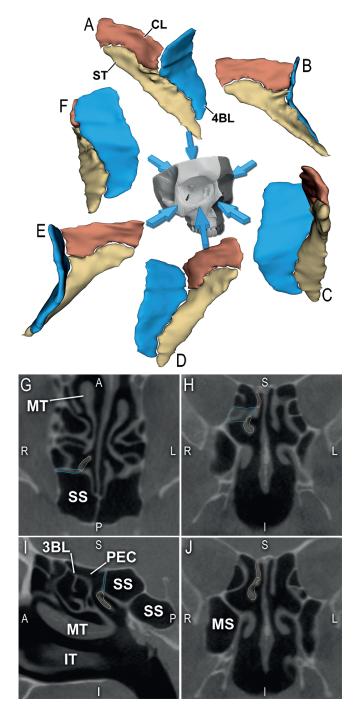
The basal lamella of the superior turbinate, right side. View from superior-posterior-medial (A), medial (B), anterior (C), inferior-anterior-lateral (D), lateral (E), posterior (F). (G) axial CT image of the same individual with frontal (H, J) and sagittal (I) reconstructions. Yellow: superior turbinate, brown: conchal lamina (depicted only in the neighboring area), blue: basal lamella of the superior turbinate (4BL). In most cases the frontal component of the 4BL was pentangular (C, I). 3BL: basal lamella of the middle turbinate (MT), IT: inferior turbinate, MS: maxillary sinus, PEC: posterior ethmoidal cell, SS: sphenoid sinus. A: anterior, L: left, I: inferior, P: posterior, R: right, S: superior. Adapted from Eördögh et al. (6).
